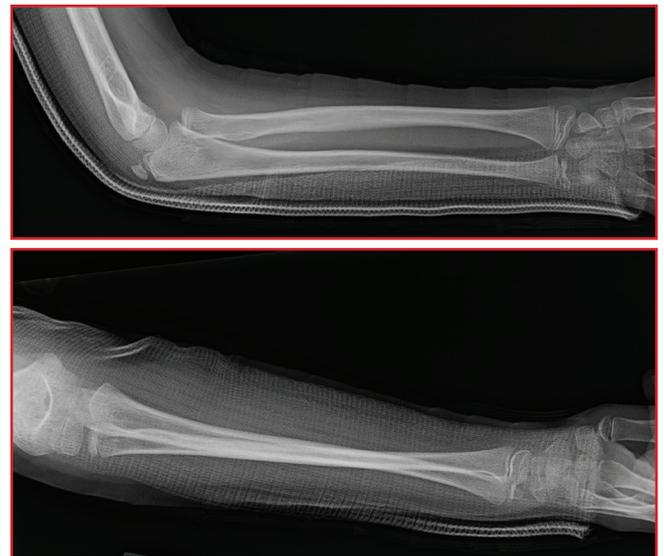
Initial outside x-rays showing radial head dislocation on lateral view.
